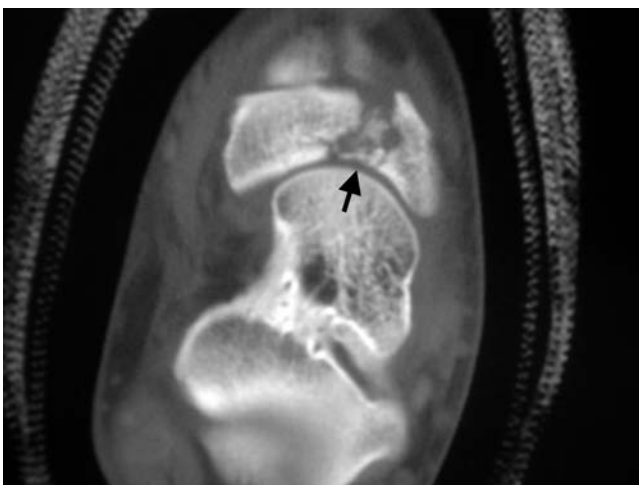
Computed tomography (axial view) demonstrating navicular body fracture with displacement.
